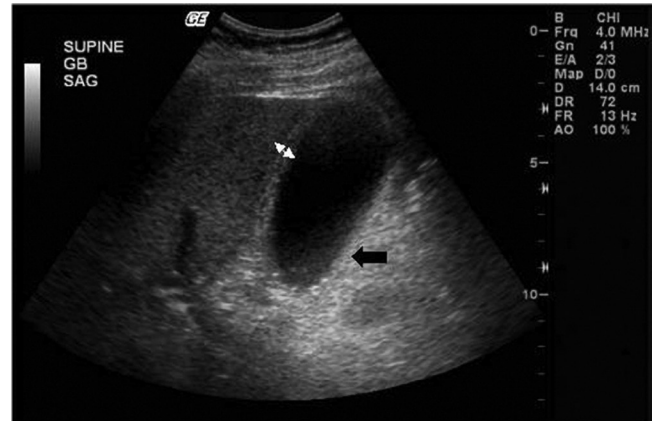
■ Ultrasound of the gallbladder demonstrating wall thickening (double arrows) and sludge (black arrow).
